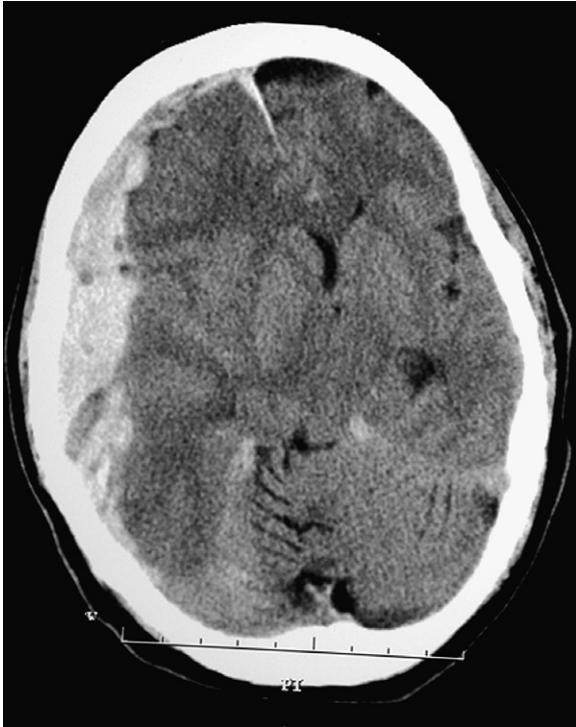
Axial CT scan of the head at presentation showing a right acute subdural haematoma with 2 cm of midline shift.
